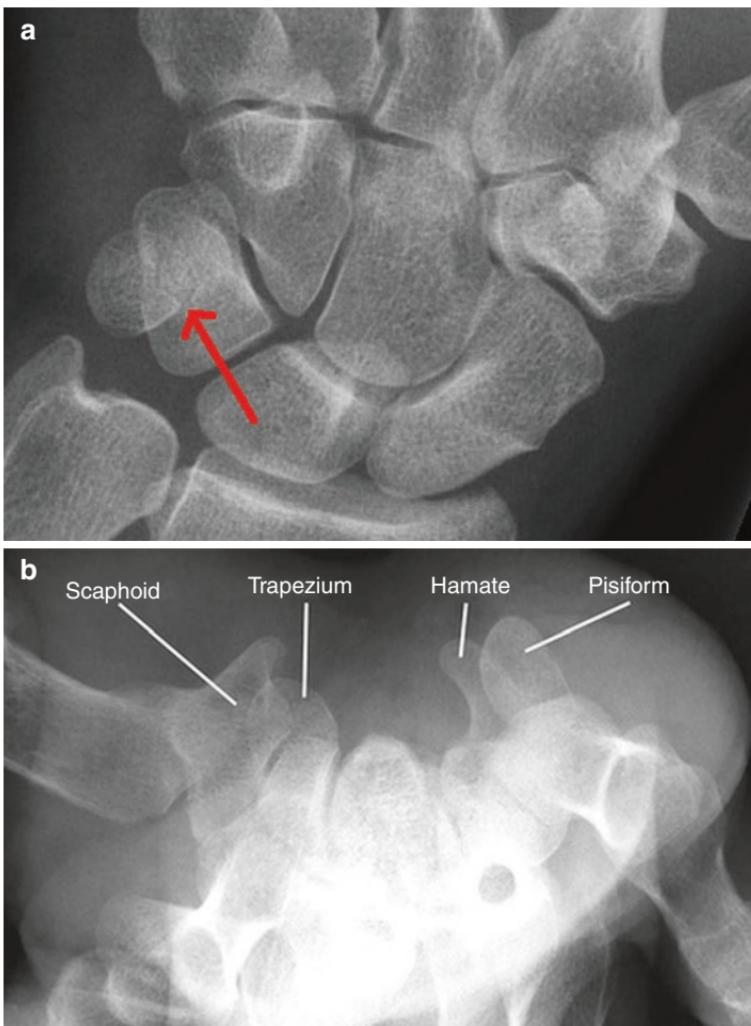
Pisiform X-ray: (a) oblique view showing fracture (arrow), (b) carpal tunnel view (no fracture). (a: Used with permission from Northwestern University, Feinberg School of Medicine, Department of Emergency Medicine. b: Reprinted from Watanabe A, Souza F, Vezeridis PS, et al. Ulnar-sided wrist pain. II. Clinical imaging and treatment. *Skeletal Radiol.* 2010;39(9):837–857. With permission from Springer Nature)
